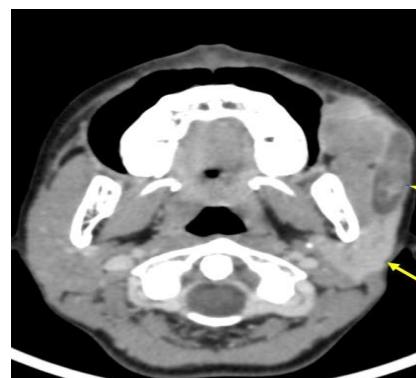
Axial contrast enhanced CT with puffed cheek manoeuvre depicts bulky enhancing left parotid gland (arrow). The left parotid duct was dilated with thickened enhancing walls (arrowhead).
